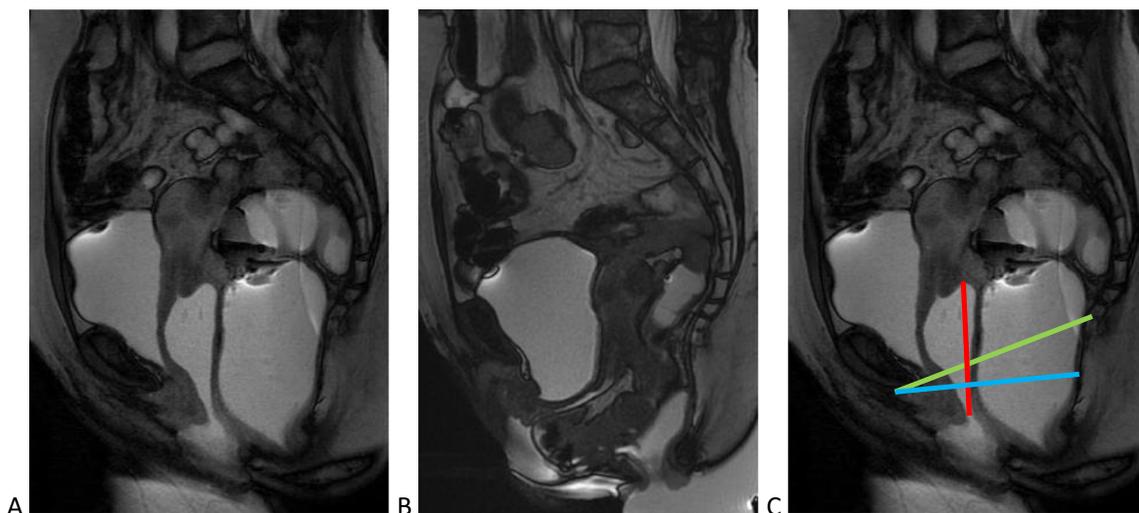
Dynamic MRI with intravaginal and intrarectal gel. a At rest. b At maximal pushing. c Pubococcygeal line (PCL, green), horizontal line (HL, blue), and vaginal axis (red)
